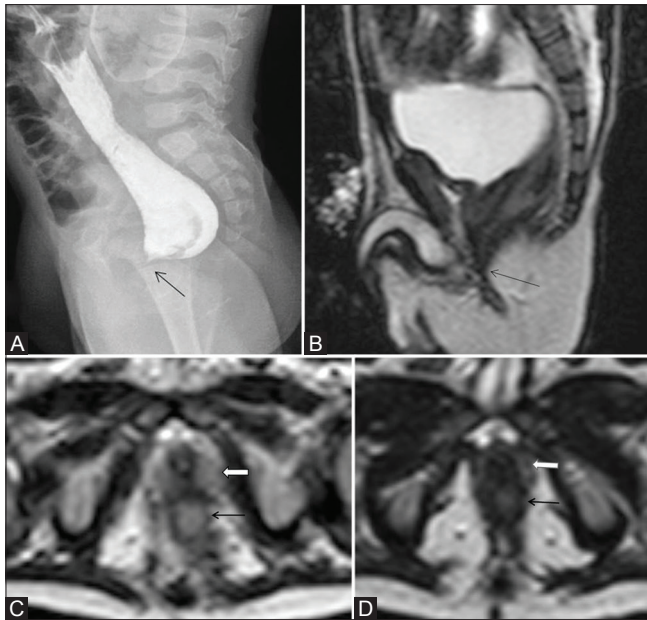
(A-D): 10-month-old child. (A) Distal cologram (DC) shows anterior beaking (arrow) in the rectal pouch suspicious of fistula, although no further opacification was achieved due to reflux from the colostomy site. (B) T2-weighted MRI image shows hypointense tract (arrow) from the rectal pouch to the urethra. (C) Axial T2-weighted image shows the rectal pouch (black arrow) close to the prostate (white arrow). Note the central hyperintense mucosa allowing differentiation from fistula. (D) Axial image caudal to it leaves no doubt to the anatomy as the hypointense fistula (black arrow), lacking a central bright mucosa as seen in the rectal pouch, is directly visualised entering the prostatic parenchyma (white arrow) to join the prostatic urethra
